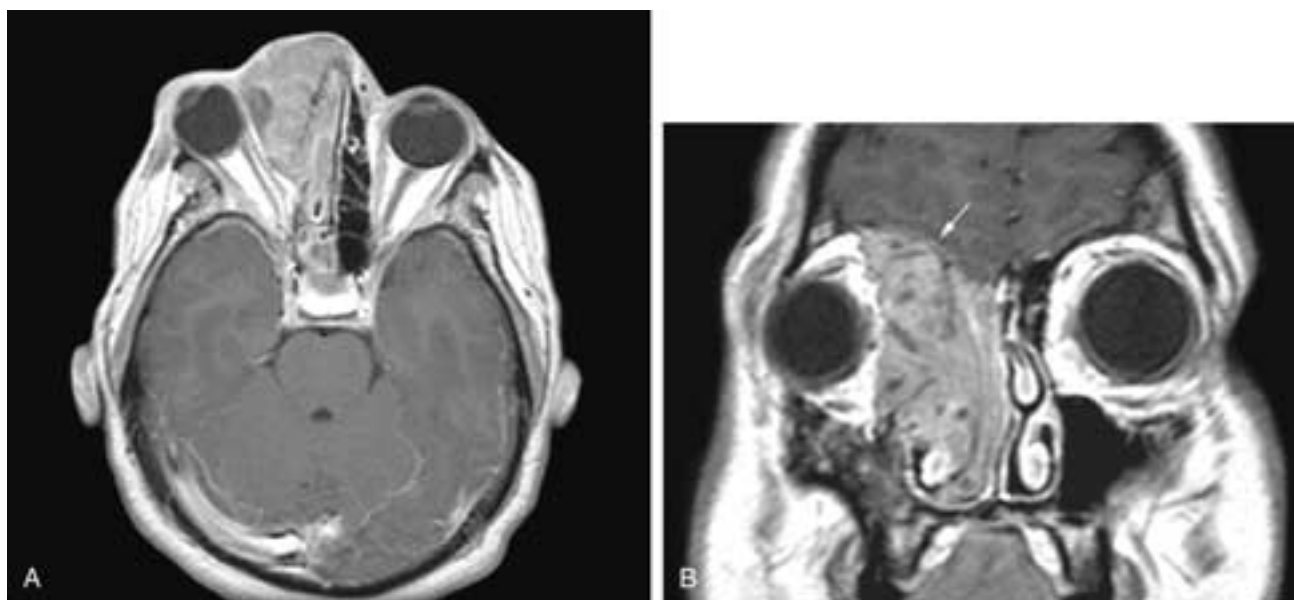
Axial (A) and coronal (B) T1-weighted, fat-suppressed, contrast-enhanced MR images show a large tumor in the right ethmoid complex with extension into the orbit. The medial rectus muscle has been invaded, and the globe is laterally displaced and flattened by the tumor. In addition, in B, dural enhancement is seen (arrow), indicating tumor invasion. This patient had a squamous cell carcinoma.
